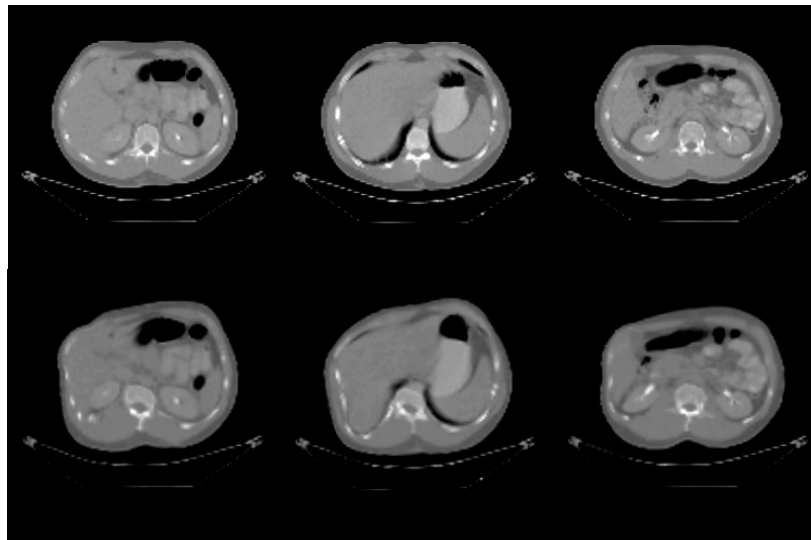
Selected transverse slices of the Zubal CT image before (top) and after (bottom) 3D thin-plate warping. Note the different appearance of image after the non-linearly and spatially varied distortion.
